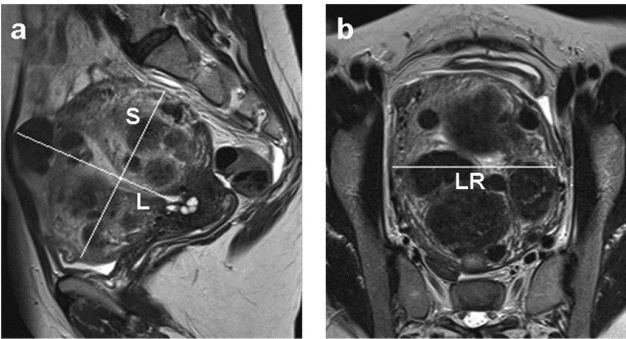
Measuring the volume of a myomatous uterus from MRI in the (a) sagittal and (b) transverse plane, where S is the longitudinal diameter, L is the anteroposterior diameter, and LR is the transverse diameter. Reproduced with permission from [447].
